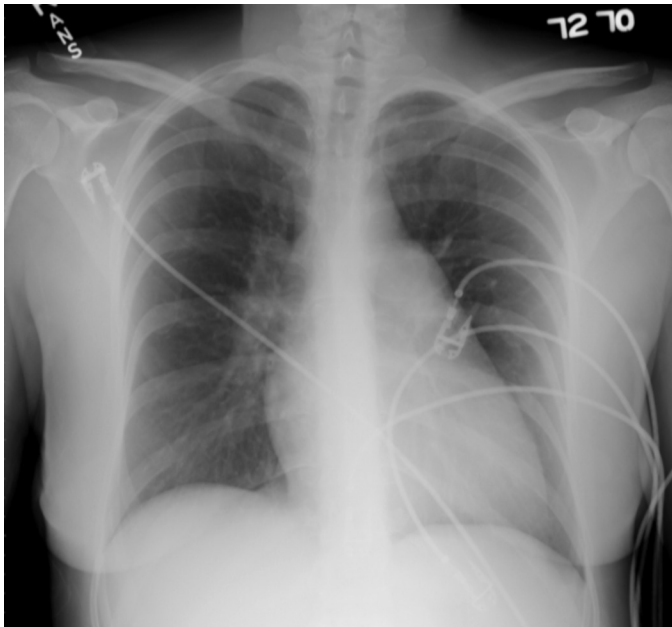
Chest radiograph of a patient with PAH.
